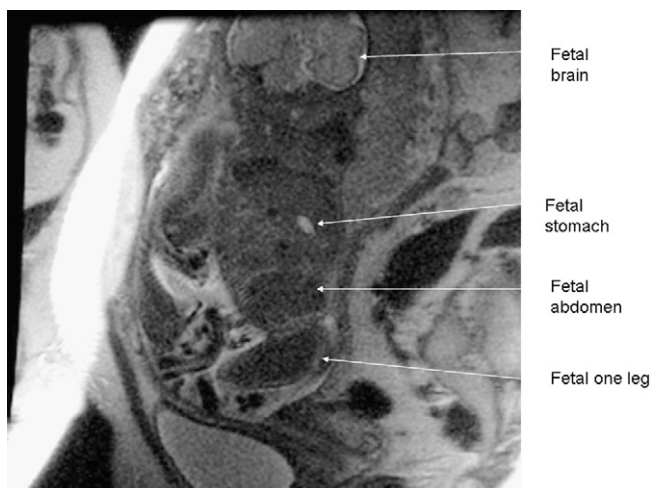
Magnetic resonance imaging (MRI) at 31 weeks of gestation demonstrating a fetus with oligohydramnios, pulmonary hypoplasia, a small stomach, ill-defined bowel loops, absent bladder, agenesis of kidneys and a single leg consistent with the diagnosis of sirenomelia.
